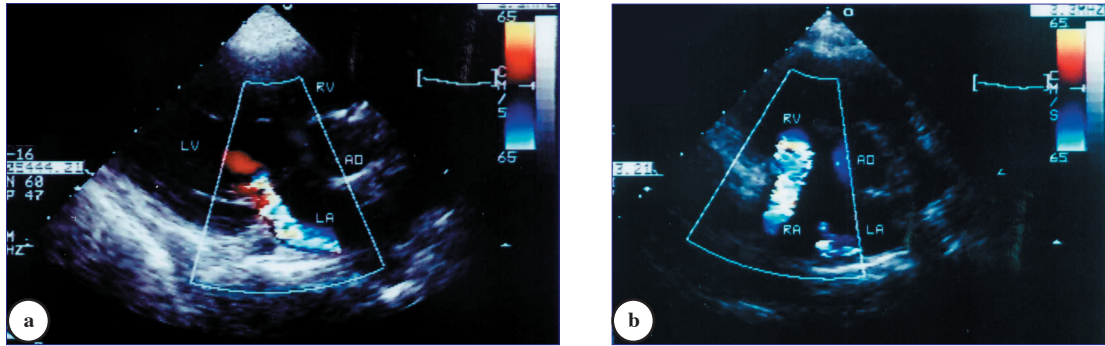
Echocardiogram of Patient 3 (Table 1). a) Long axis view of the heart showing moderate mitral valve regurgitation. b) Short axis view of the heart showing moderate tricuspid valve regurgitation.
